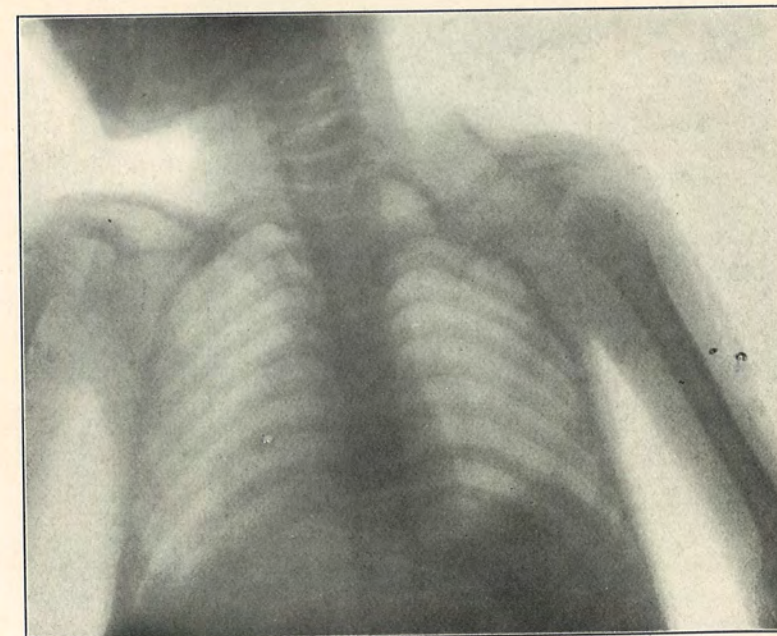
Case II, Congenital elevation of scapula. (Radiograph by C. F. Mitchell, M.D.)
